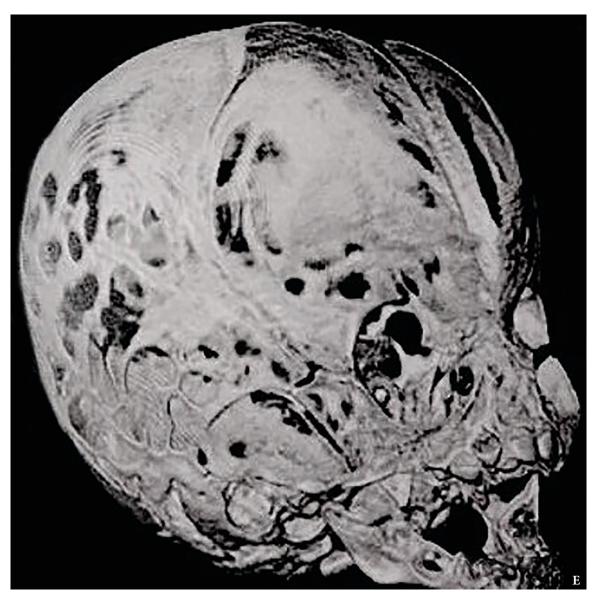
(cont'd). 3D reconstruction CT scans of the skull: left anterolateral view (E).
